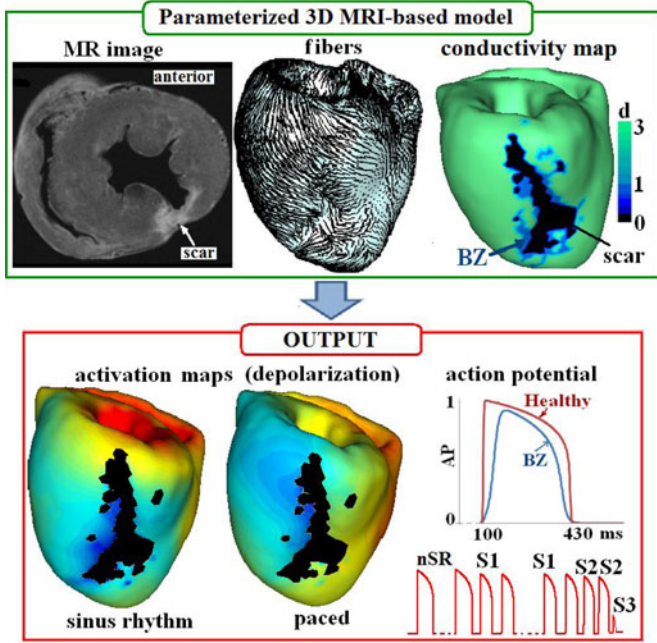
(Upper panel) 3-D MRI-based model for the LCX-infarct heart (from segmented ADC maps, and fibers from DT-MRI), together with input 3-D conductivity map (with scar in black, healthy in green, BZ in light-blue). (Lower panel) Isochronal maps for depolarization times (color scale corresponding to early activation times in red and late activation times in blue) during nSR and pacing, and computed AP before and after the S1-S2-S3 train (resulting in noninducible VT).
